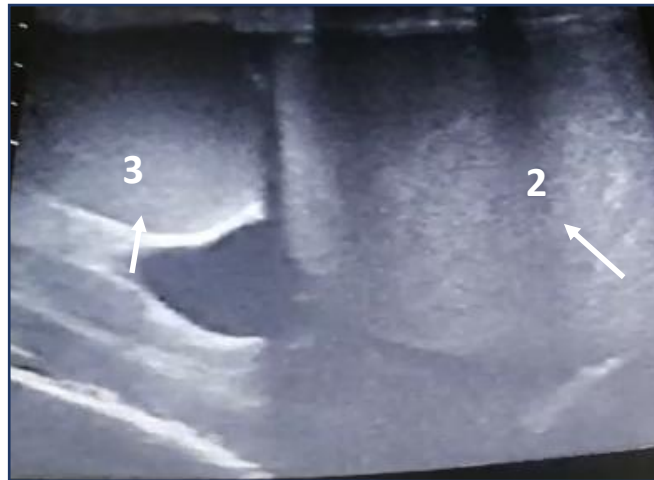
Ultrasonography of left hemiscrotum showing left supernumerary testicle
